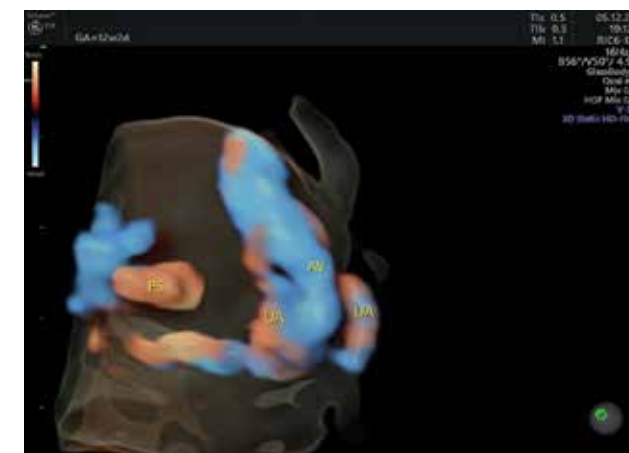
Three-dimensional (3D) Doppler ultrasound image of ductus venosus (DV) absence at 12+2 weeks. Umbilical blood flow is diverted to the inferior vena cava by an aberrant vessel (AV). UA: umbilical artery, PS: portal system.
